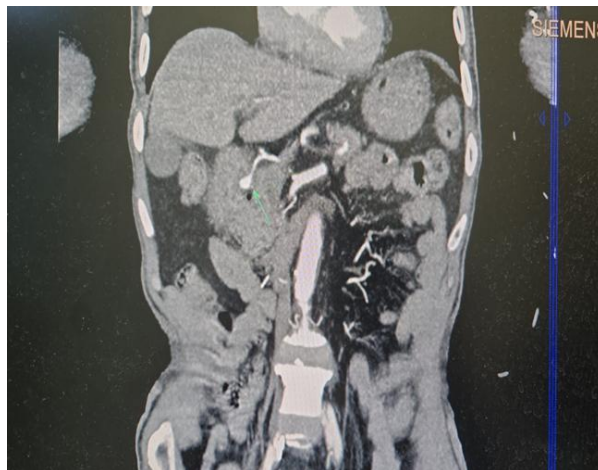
CT angiography image showing the gastroduodenal artery pseudoaneurysm (10 × 7 mm).
